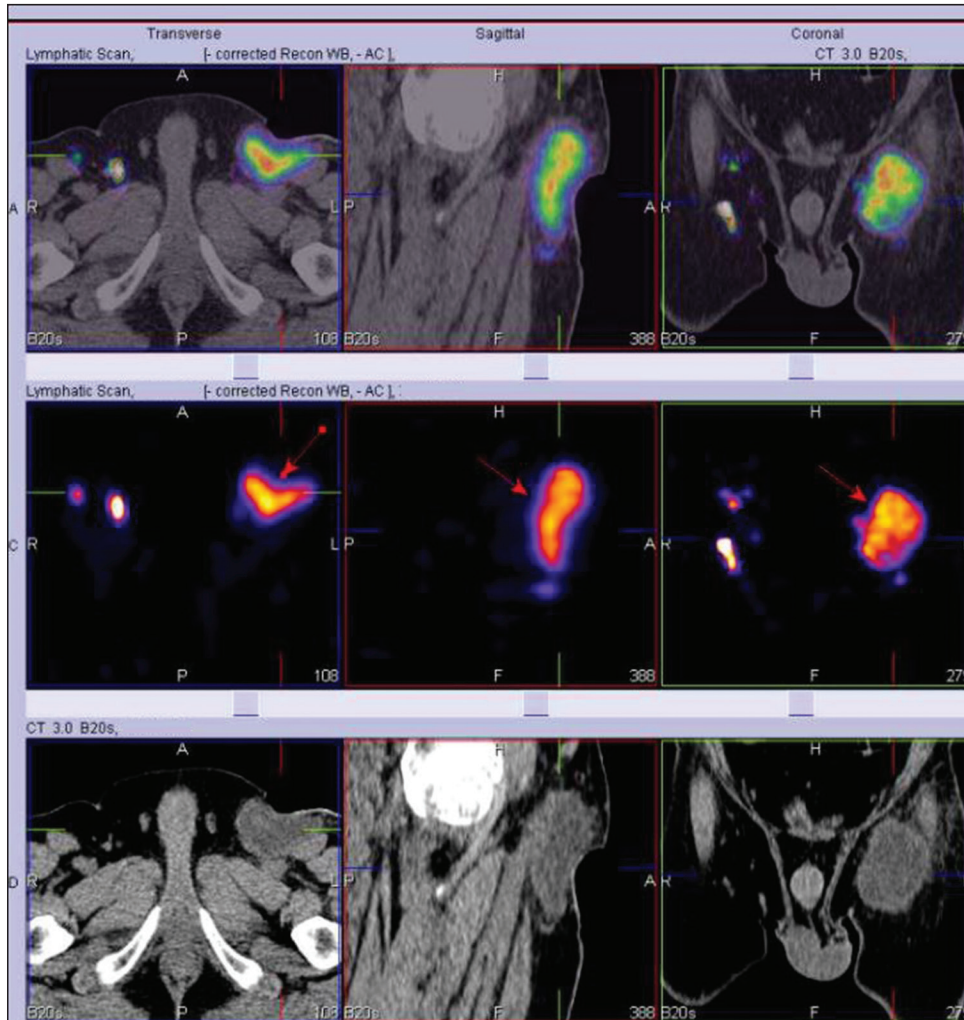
Single-photon emission computed tomography-computed tomography fused images showing lymphocele in the left groin region (arrows)
